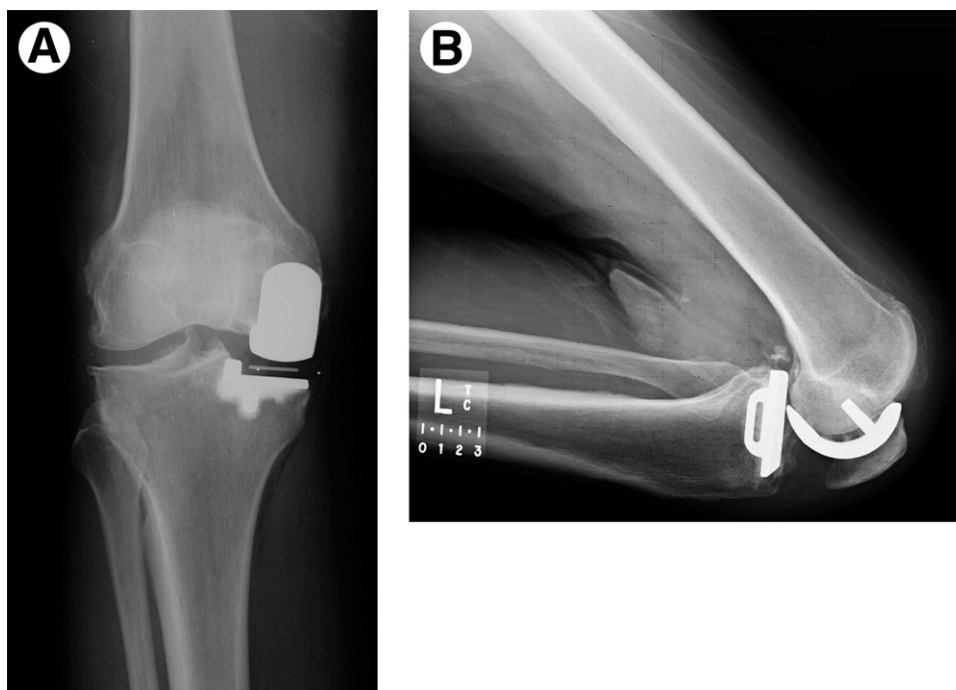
(A) Anterior–posterior and (B) lateral radiographs displaying the Oxford phase III device for a patient with anteromedial osteoarthritis.
